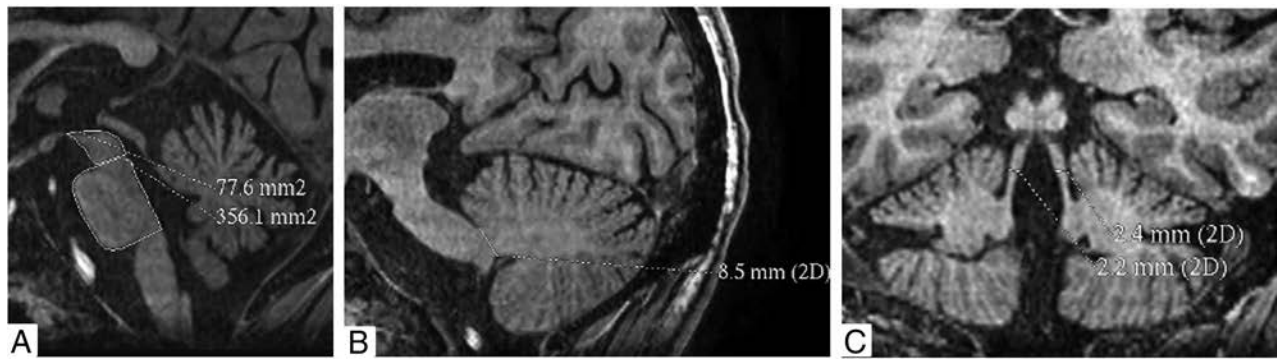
Cranial MR imaging of a 31-year-old woman with Wilson disease shows increased pons-to-midbrain areas (4.59 mm^2) (A), reduced width of the middle cerebellar peduncle (8 mm) (B), and a reduced width of superior cerebellar peduncle (2.3 mm) (C). Her MR Parkinsonism index was increased (16.9). She had impaired postural reflex.
